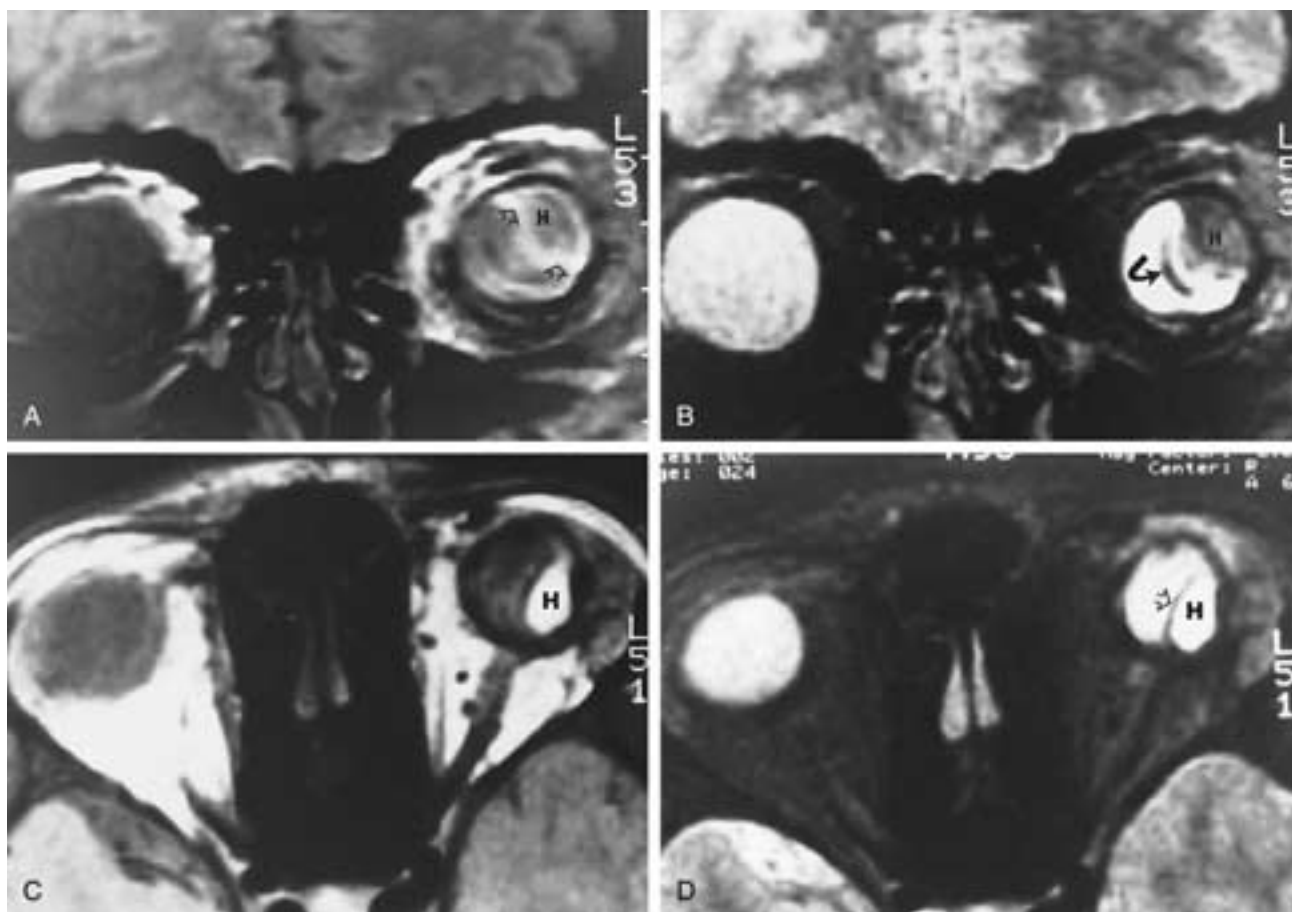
Subacute and chronic hemorrhagic choroidal detachment. A, Coronal PW MR image shows choroidal hematoma (*H*) as an area of mixed signal intensity. The peripheral part of the hematoma is hyperintense (*arrows*). B, Coronal T2-weighted MR image shows a choroidal hematoma (*H*) as a hypointense area. The curved image (*curved arrow*) is thought to be caused by residual intravitreal silicone oil. C, Axial PW and D, T2-weighted MR images. Scans obtained about 9 days after the scans in A and B show that the hematoma is markedly hyperintense.
